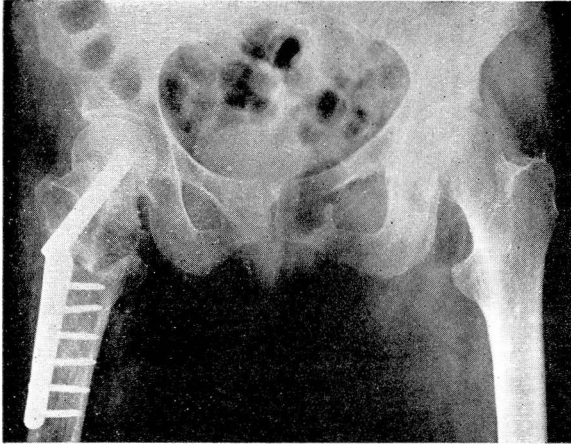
Roentgenogram showing equalization of leg length after operation in case shown in fig. 12.
